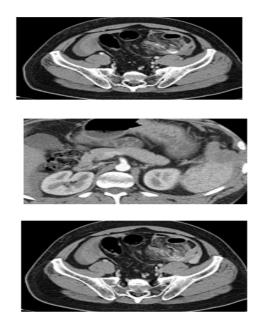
Case 1 - 25 yr old patient with RTA. CT findings showing active contrastextravasation, free fluid, mesenteric stranding and splenic contusion
